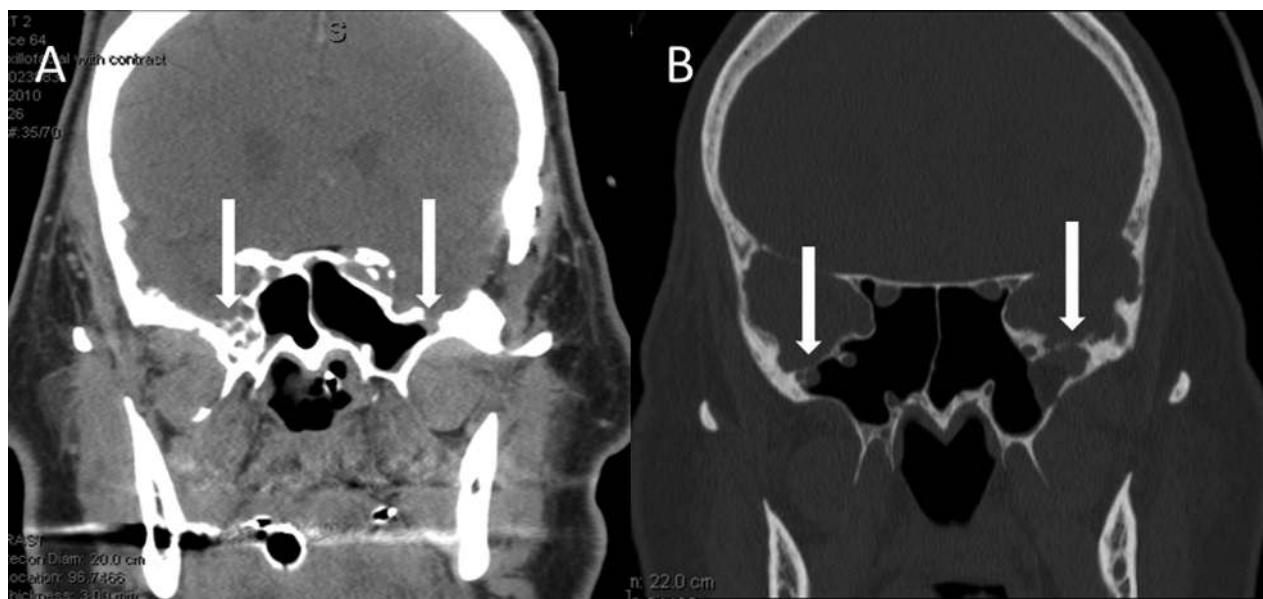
Coronal CT scans of 2 patients with bilateral arachnoid pits with subsequent CSF leak and encephalocele development. (A) Note how this patient has multiple pits on the right, but because the lateral recess did not fully pneumatize, he did not develop a CSF leak on that side. (B) This patient has arachnoid pits present all over the middle cranial fossa dura with several defects on the left and a single defect on the right. CT = computed tomography. CSF = cerebrospinal fluid; CT = computed tomography.
